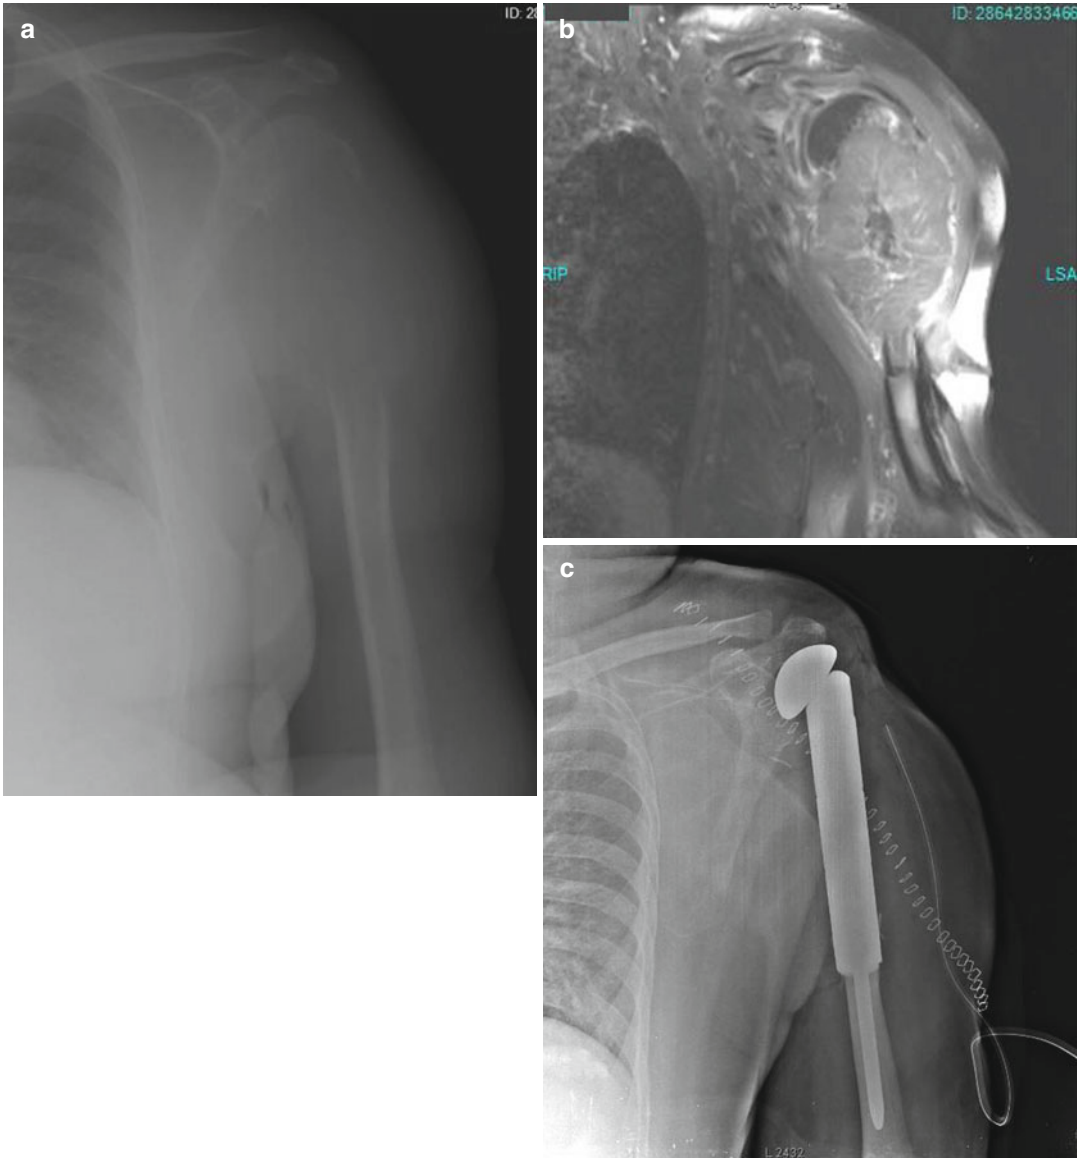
Bone metastasis of lung adenocarcinoma. (a) Radiograph, (b) MR imaging of the lesion that destructs proximal humerus and extends soft tissues.
